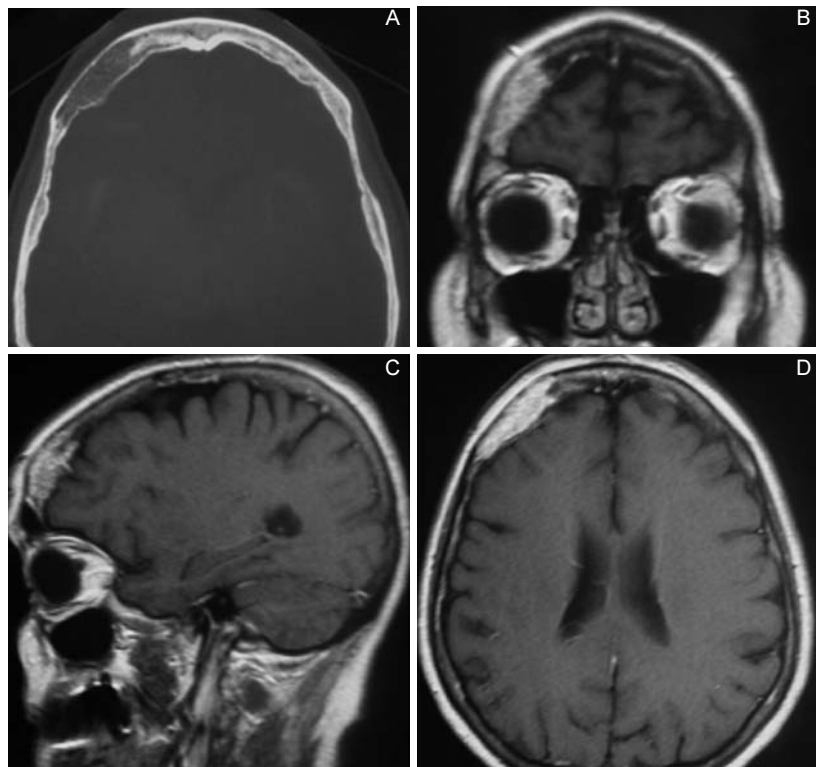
Male, aged 58. Reported headache with pain in the front orbital region, pulsing in clinostatic position. Association of the headache with a swelling located in the skull frontal region: an angioma. Axial cranial CT with bone window (A) and T1 weighted RMI sequences (coronal (B), sagittal (C) and axial (D) sections).
